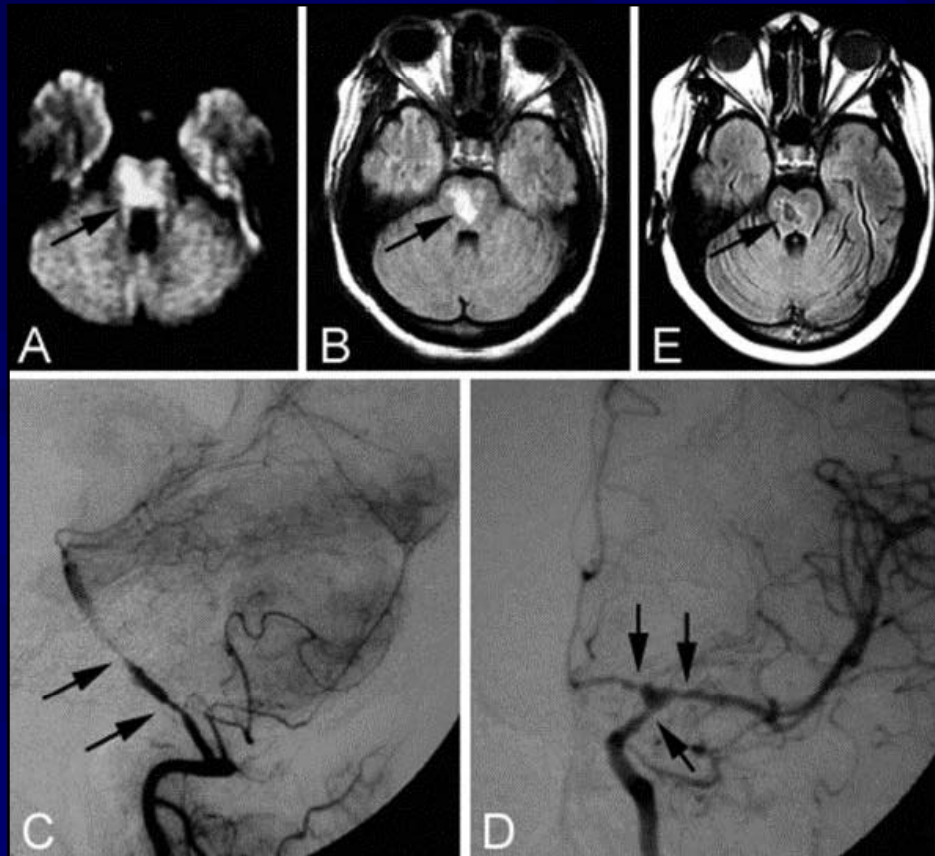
Figure Brain MRI and cerebral digital subtraction angiography (DSA)(A) Brain MRI, diffusion weighted imaging shows restricted diffusion at the level of right pons (arrow). (B) Brain MRI, initial FLAIR, with abnormal area of hyperintense signal at the level of the pons (arrow). (C) Cerebral DSA. Posterior circulation, with segmental caliber narrowing affecting distal vertebral arteries and mid-basilar artery (arrows). (D) Cerebral DSA. Anterior circulation. Segmental caliber narrowing and beading in distal left internal carotid artery, left middle cerebral artery, and anterior cerebral artery (arrows). (E) Brain MRI, follow-up FLAIR, 4 months later; area of hypointensity within the pons (arrow).
